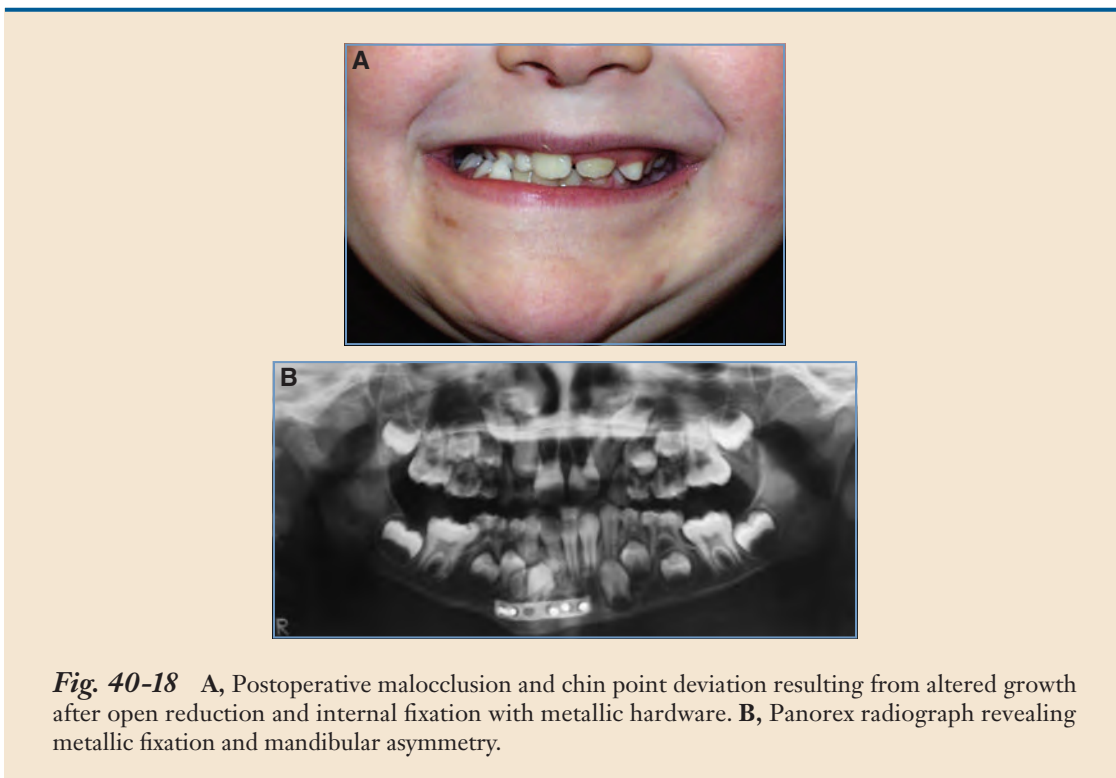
A, Postoperative malocclusion and chin point deviation resulting from altered growth after open reduction and internal fixation with metallic hardware. B, Panorex radiograph revealing metallic fixation and mandibular asymmetry.
